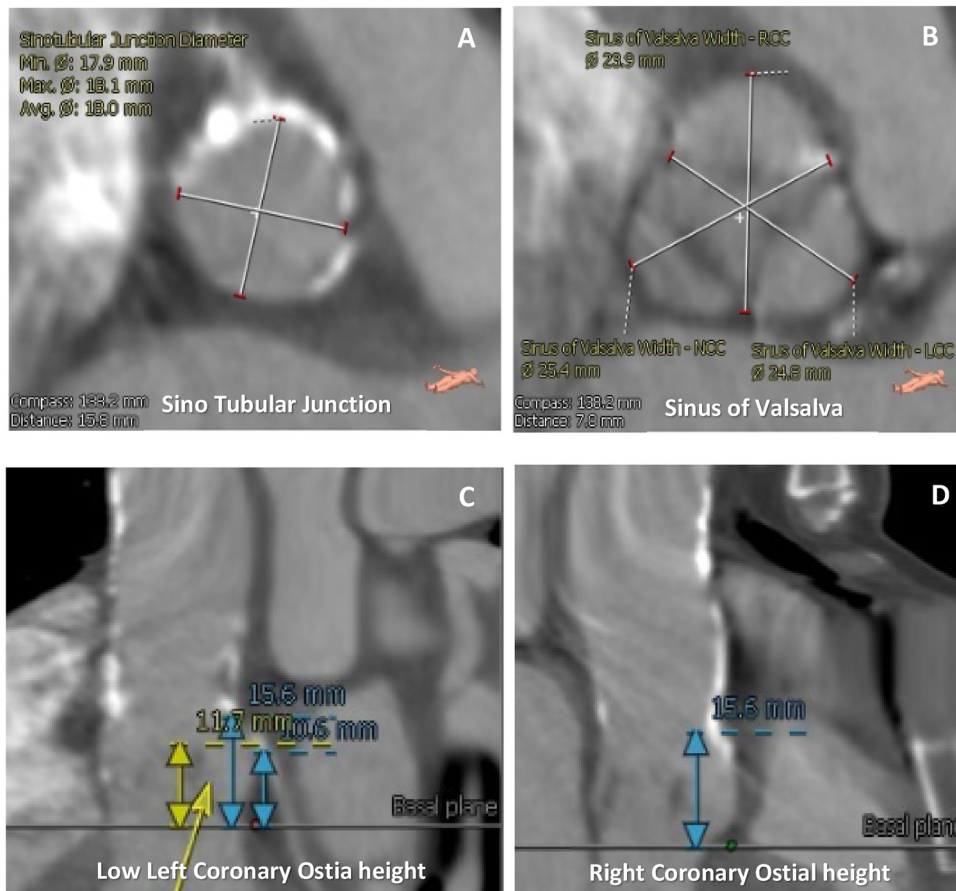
(A,B,C,D): CT Images showing smaller sinus and low coronary ostia height.
